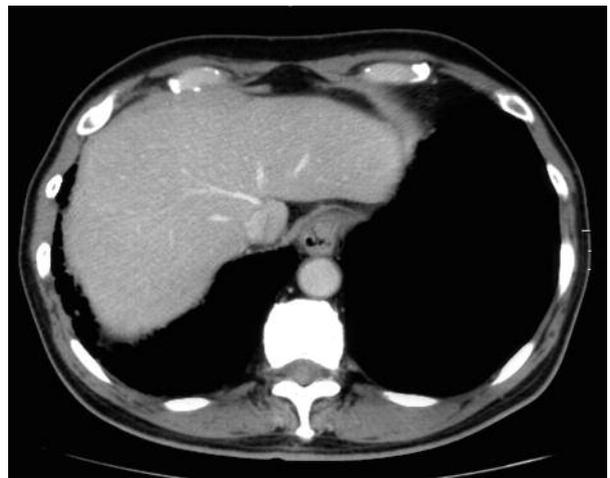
After three courses, no low density area was observed in contrast CT, and the patient was judged to have achieved a complete response.
